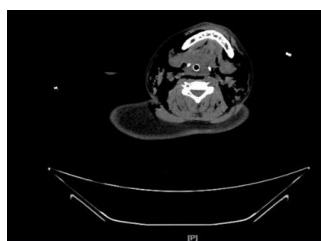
CT-scan of the cervical vertebrae showed rupture of the trachea and laceration on the lung
